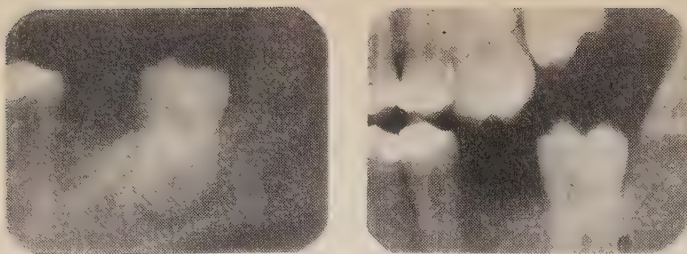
Radiographs taken in February 1964.
